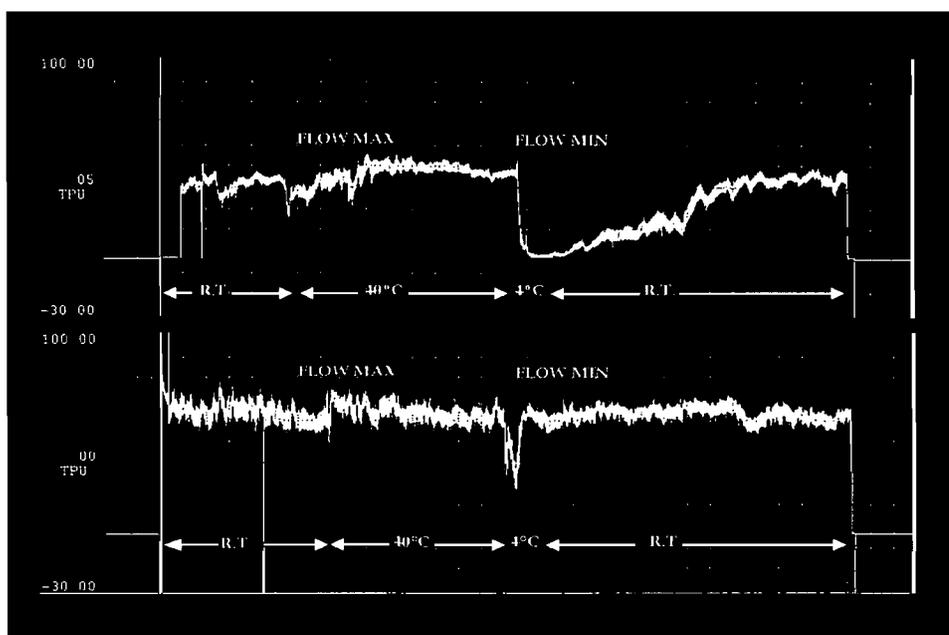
Top: Tracing of Laser Doppler flowmetry (LDF) in a vasospastic patient showing a low baseline flow at room temperature and a marked decrease in flow after immersion of the hand in cold water (4°C) with a delayed recovery to baseline. Bottom: Tracing of peripheral blood flow in a nonvasospastic patient showing a normal baseline flow at room temperature and a rapid decrease after immersion of the hand in cold water (4°C) with a rapid recovery to baseline.
